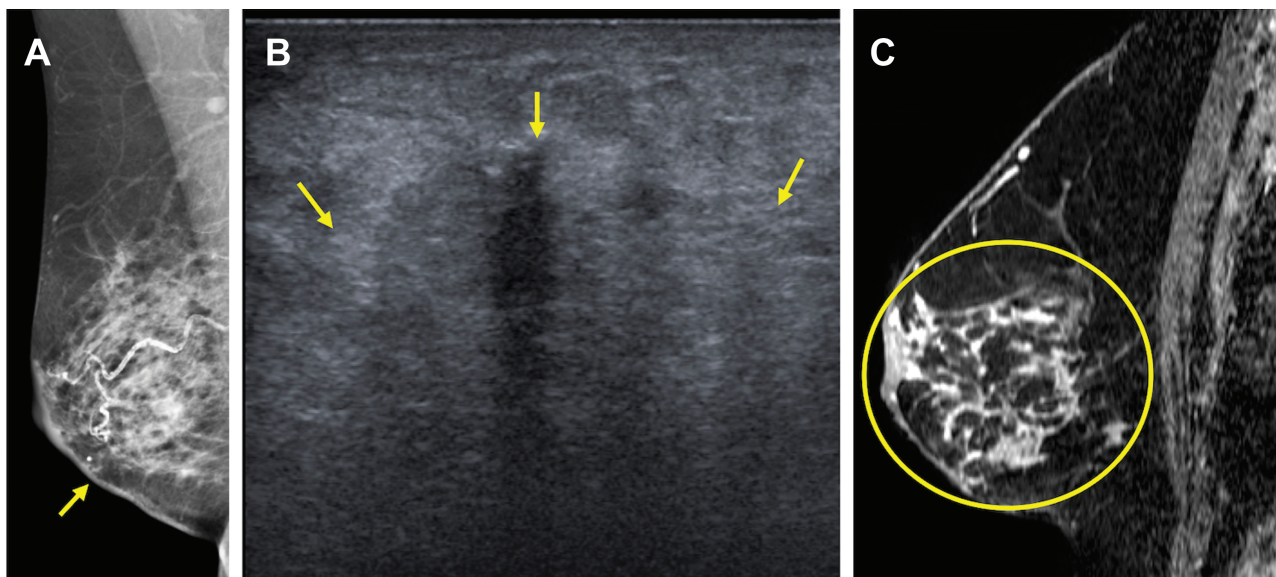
70-year-old woman who presented with a self-detected mass in the right lower inner quadrant diagnosed on core-needle biopsy as invasive lobular carcinoma (ILC) (Nottingham grade 1, estrogen and progesterone receptor positive, HER2-negative) with associated lobular carcinoma in situ, which serves as an example of concordant estimation of the span of ILC on MRI with underestimation on conventional imaging. A: Diagnostic mediolateral oblique mammogram demonstrated skin thickening at the site of concern (arrow), but no definite mass. B: Targeted US demonstrated an ill-defined irregular-shaped mass with indistinct margins (arrows) that was difficult to measure but estimated to span 40 mm. C: MRI performed after biopsy demonstrated a total span of 92 mm of non-mass enhancement (circle) involving the lower inner and lower outer quadrants. Final pathologic size was 90 mm on mastectomy. Conventional imaging underestimated size based on the 5 mm, 25%, and T category of stage thresholds, while MRI was accurate using all three thresholds.
